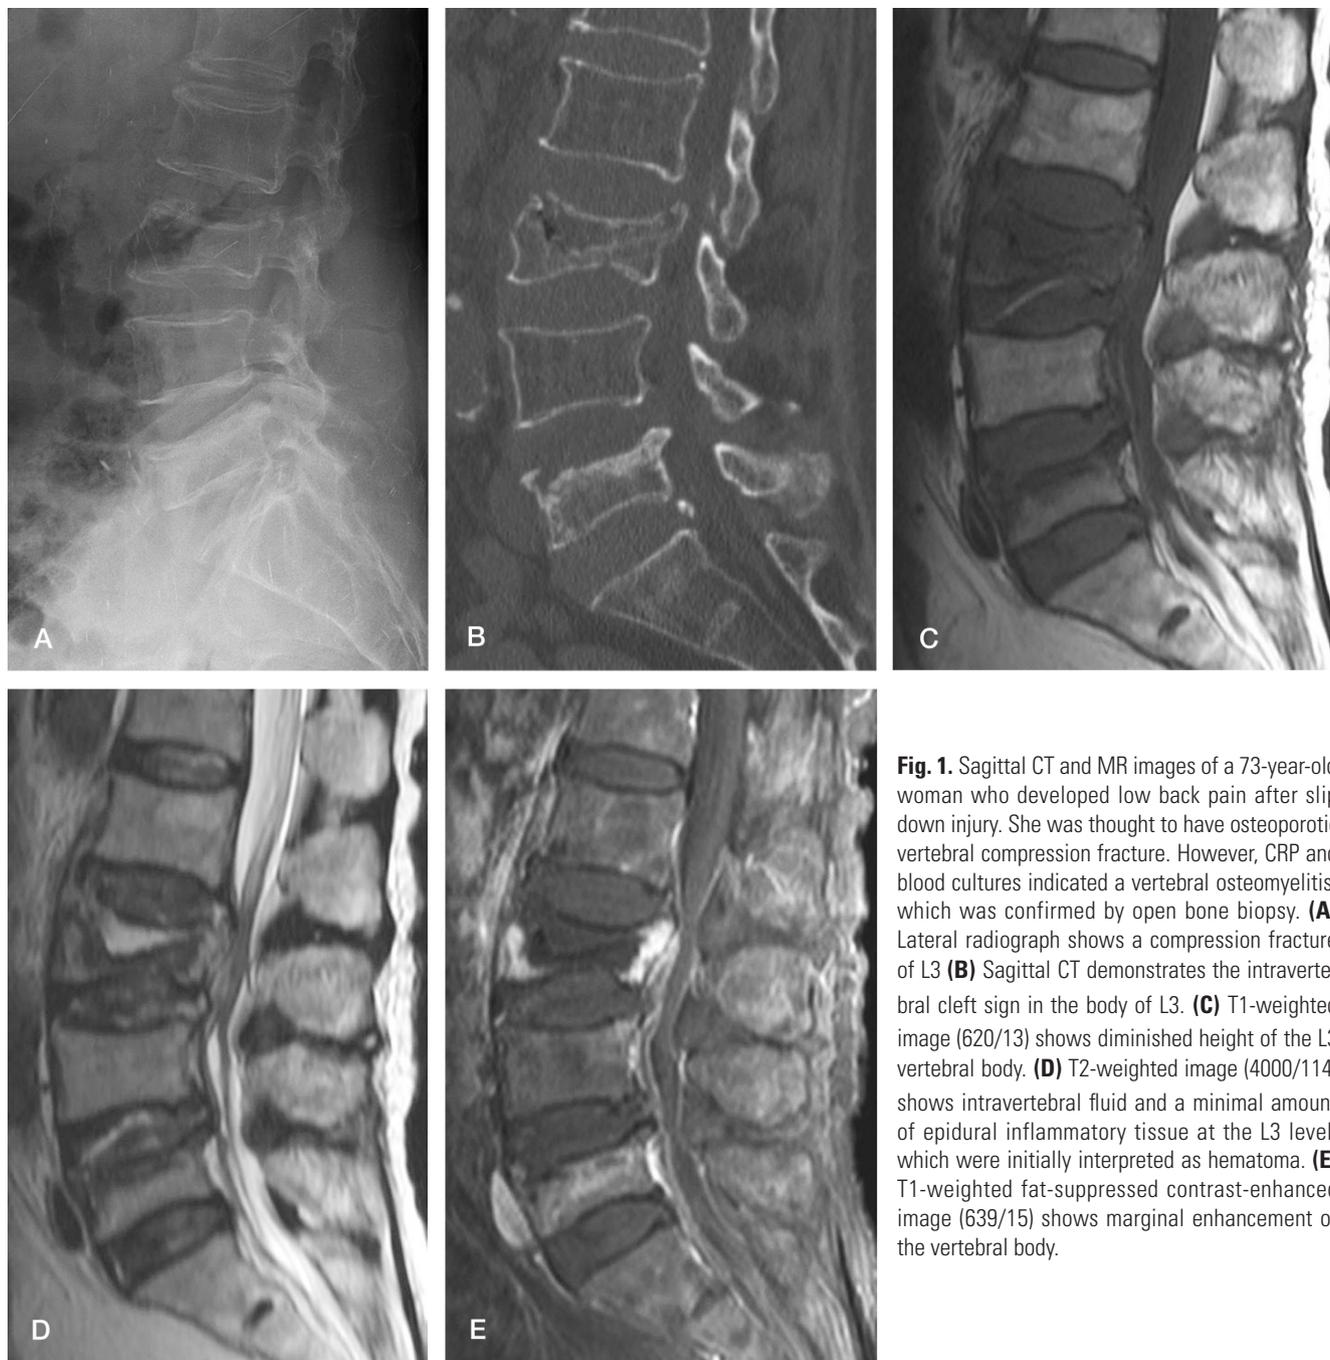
Sagittal CT and MR images of a 73-year-old woman who developed low back pain after slip down injury. She was thought to have osteoporotic vertebral compression fracture. However, CRP and blood cultures indicated a vertebral osteomyelitis, which was confirmed by open bone biopsy. (A) Lateral radiograph shows a compression fracture of L3 (B) Sagittal CT demonstrates the intravertebral cleft sign in the body of L3. (C) T1-weighted image (620/13) shows diminished height of the L3 vertebral body. (D) T2-weighted image (4000/114) shows intravertebral fluid and a minimal amount of epidural inflammatory tissue at the L3 level, which were initially interpreted as hematoma. (E) T1-weighted fat-suppressed contrast-enhanced image (639/15) shows marginal enhancement of the vertebral body.
